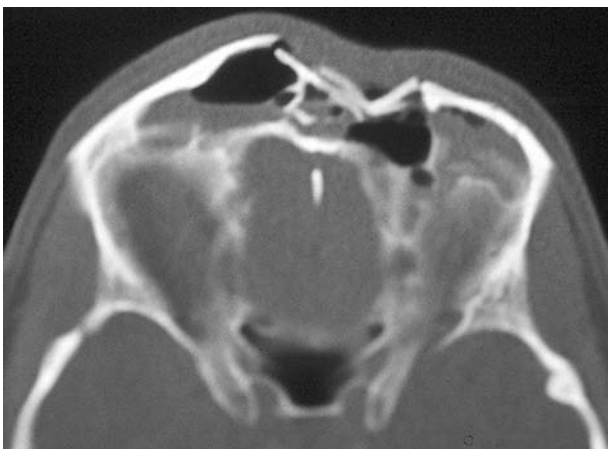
Radiograph demonstrating severe comminution of the anterior table in a large frontal sinus. Note the central component of the fracture and the inability to determine whether the nasal frontal duct is involved.
